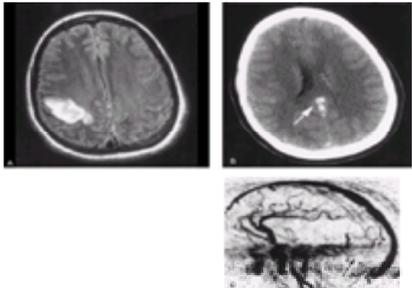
Venous sinus thrombosis with cortical infarct. A 26-year-old postpartum woman with headache and left hemiparesis. A: Axial FLAIR image at level of centrum semiovale shows increased signal in precentral gyrus, indicating cortical infarct. B: Nonenhanced computed tomography shows high attenuation in vein of Galen and straight sinus (*arrow*). C: Magnetic resonance venogram shows absence of flow through straight sinus with patent sagittal and transverse sinuses.
